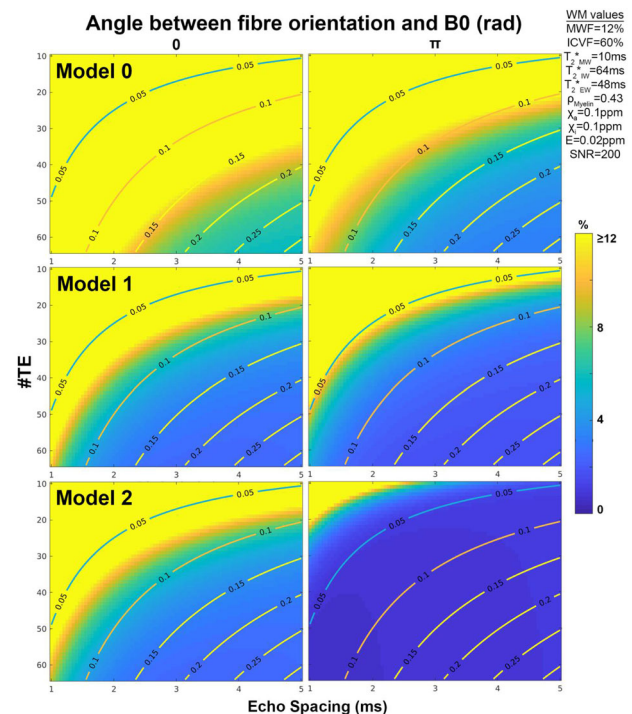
Lower bounds of MWF standard deviation predicted by CRB on different GRE protocols. The DWI informed models (Models 1&2) show that more options achieved lower SD than that of Model0. Contour outlines the protocols' longest TE (in seconds).
